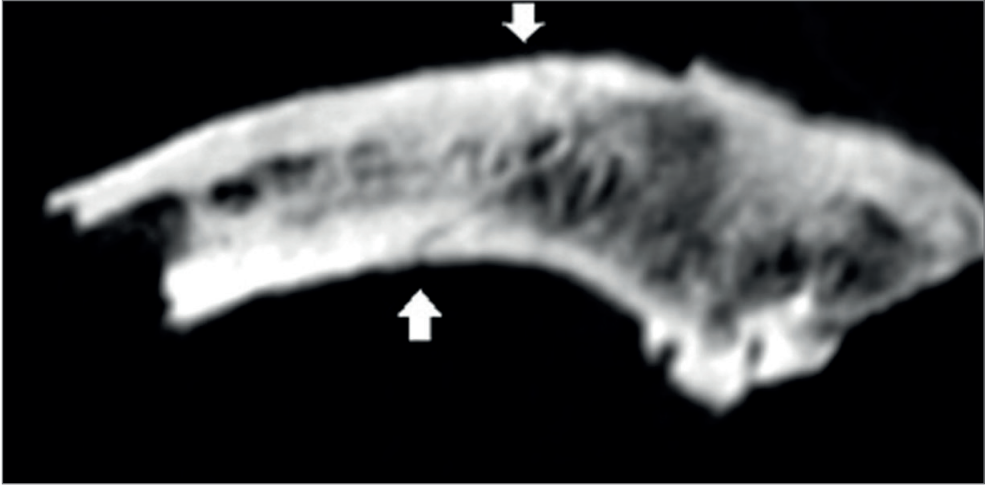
Computed tomography, anatomical norm superior view (arrows indicate areas of fracture of the lesion).
